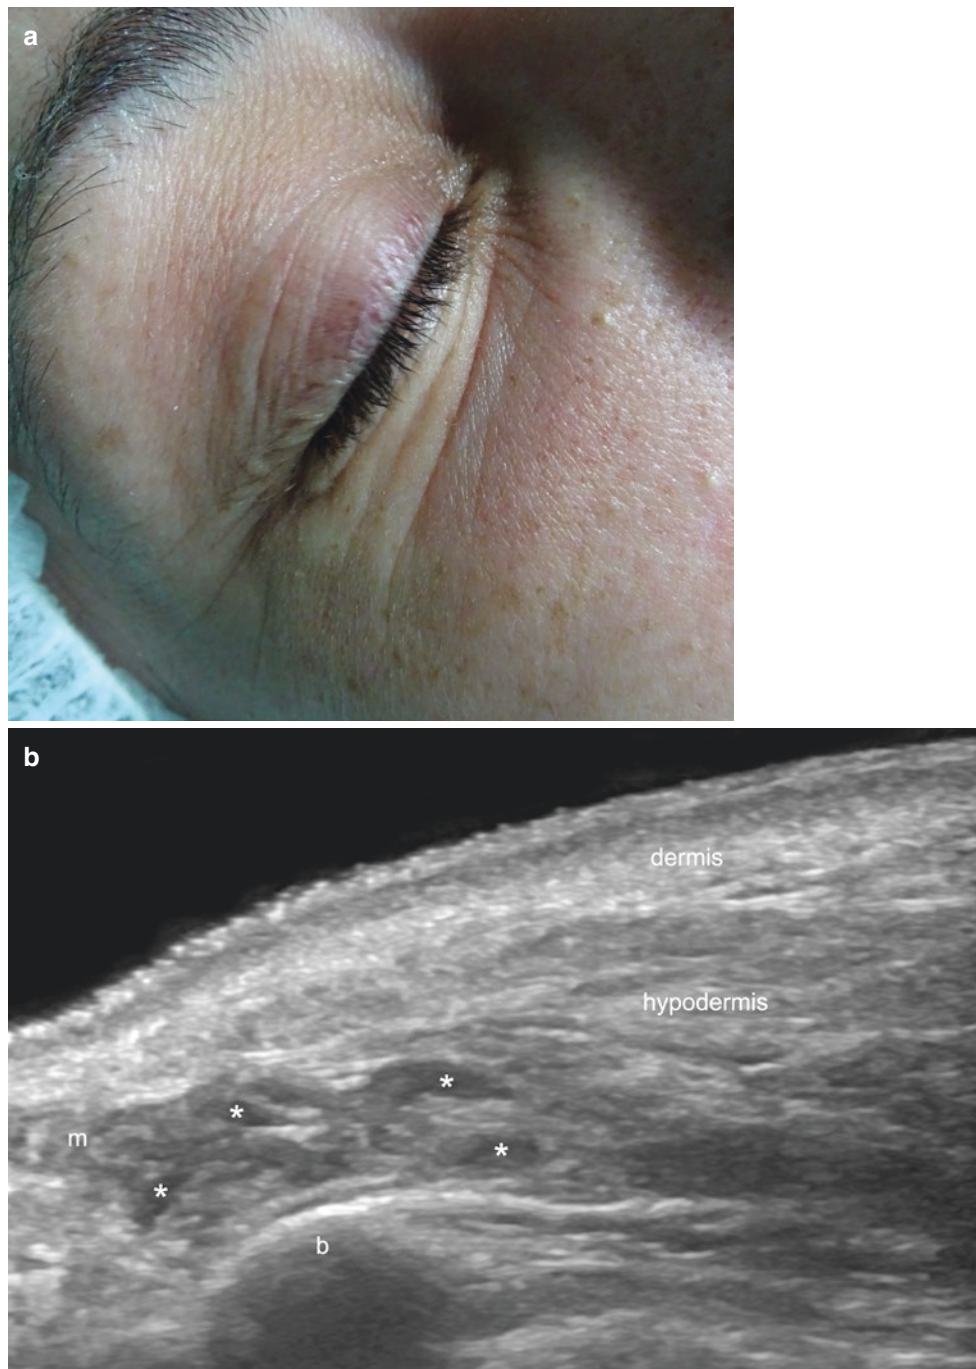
Hyaluronic acid. (a) Clinical image of a patient injected in the cheeks with high-density hyaluronic acid 1 year previously. (b) Ultrasound (greyscale, longitudinal view; right cheek) shows multiple small, anechoic hypodermal deposits (*asterisks*). Notice the blurry
